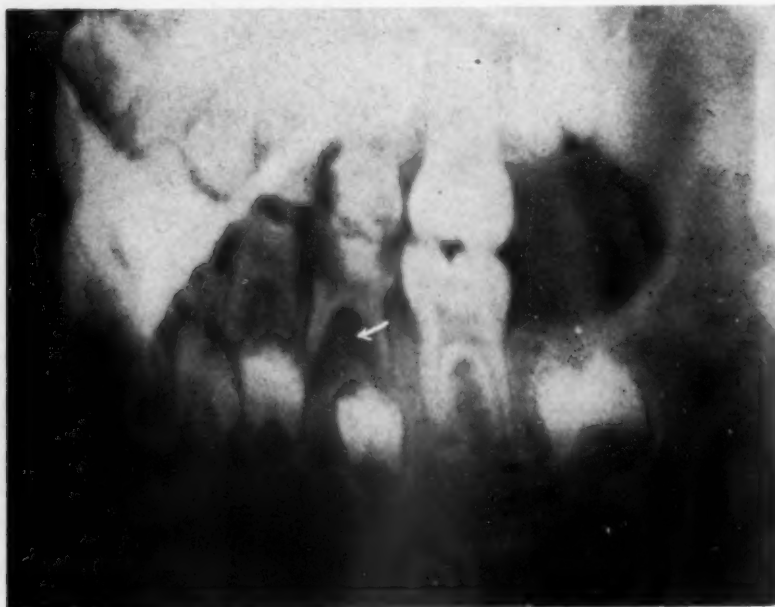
X-ray showing decayed, infected deciduous second molar.
